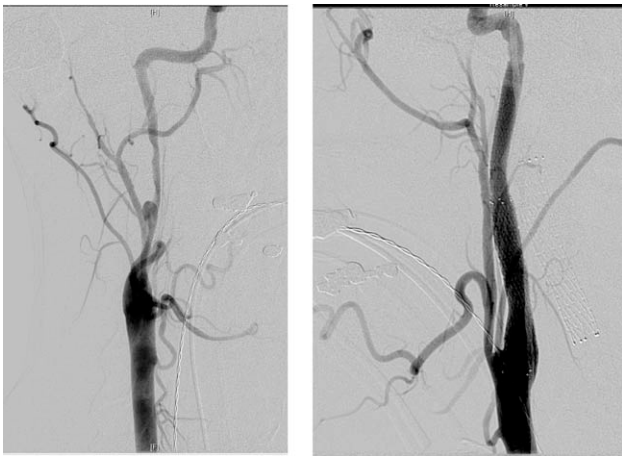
Initial angiogram and post stent ultrasound. The untreated right mid internal carotid artery appeared normal on the routine angiogram, but the post stent ultrasound showed an obvious lumen irregularity.
